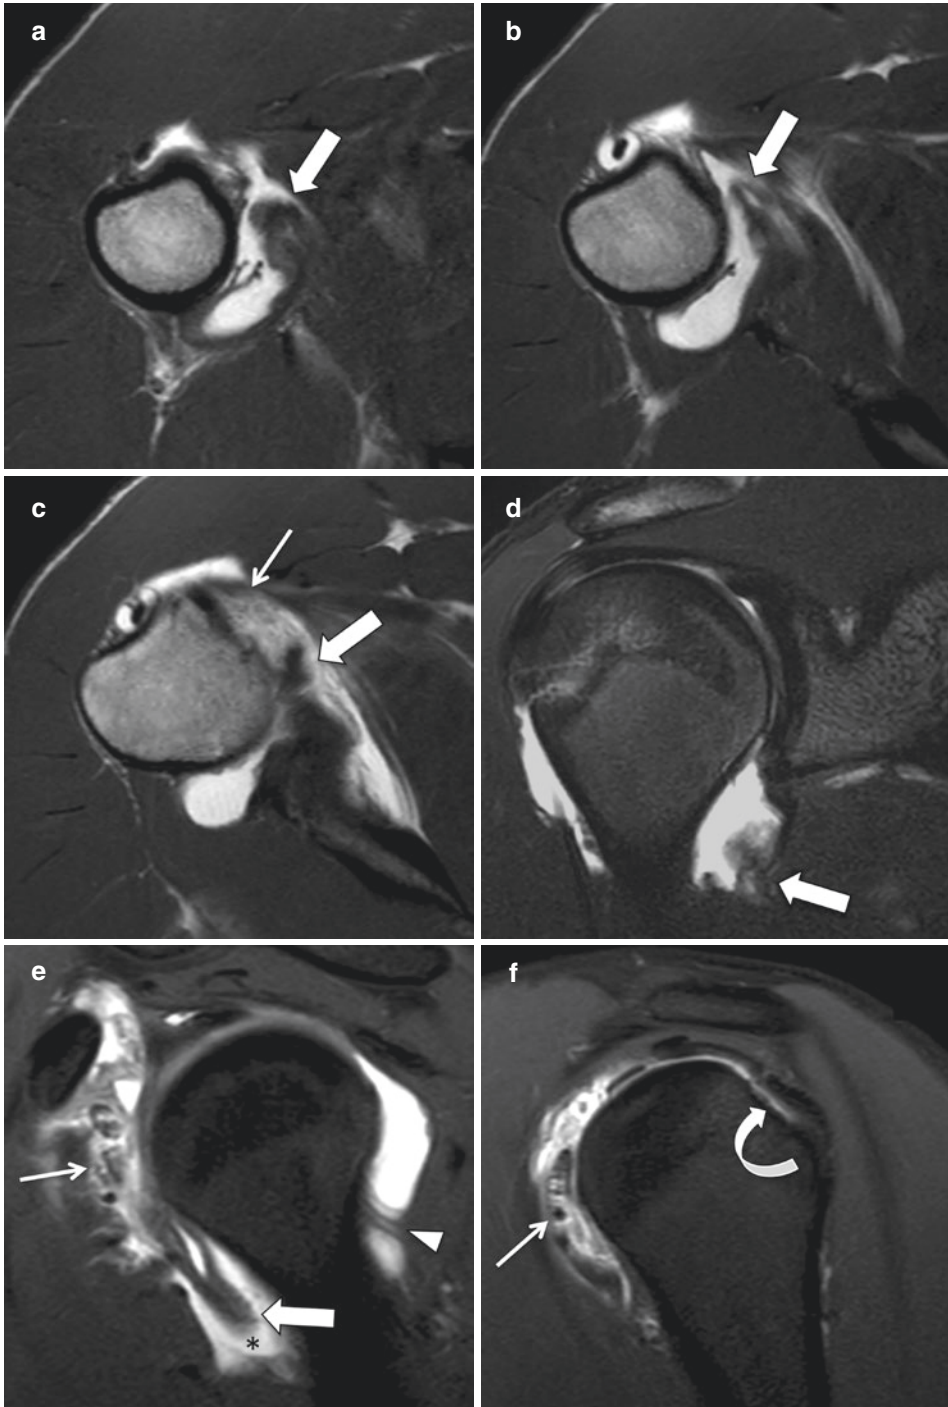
Recurrent anterior glenohumeral dislocation associated with subscapularis tear. Axial nonfat-saturated T1-weighted (a–c), coronal fat-saturated T2-weighted (d), and sagittal fat-saturated T1-weighted (e–f) arthrographic MR images demonstrating humeral avulsion of the anterior
